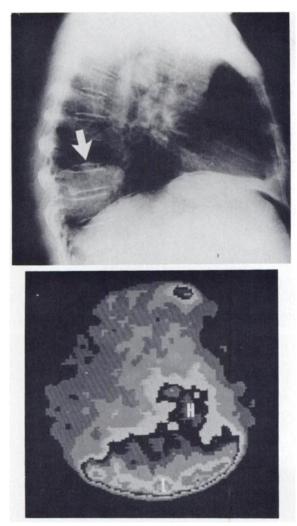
Male patient, age 66, with right-lung metastasis from prostate carcinoma. Right lateral views. Chest radiograph shows large mass in approximately same location behind heart, and of same size, as that of patient in Fig. 1. I-131-labeled 17-1A image at 5 days after injection of radioantibody shows no I-131 activity in mass behind heart. H = heart; L = liver.
